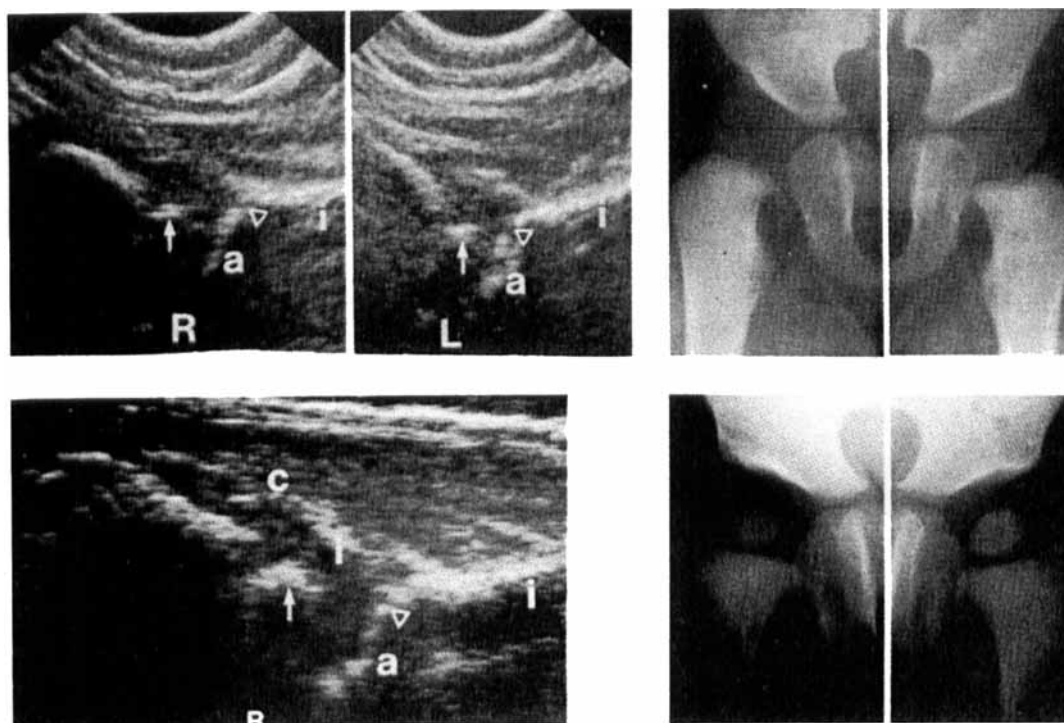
Upper left and right: ultrasonograms and radiograph of a girl aged 5 months. Radiography shows dysplasia of the right hip, whereas ultrasound shows normal right (R) as well as left (L) hip. Lower left and right: without any treatment the right hip normalized, as is seen on the radiograph and sonogram 1 year later. i os ilium; c lateral joint capsule; l labrum; other labels as in Figure 2.
